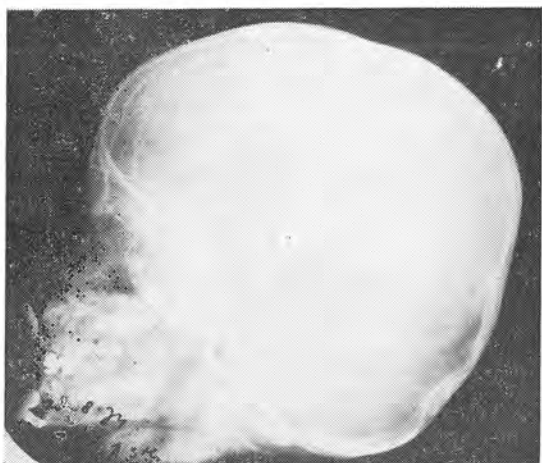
Radiographic re-examination revealed the disappearance of the osteolytic lesions.
